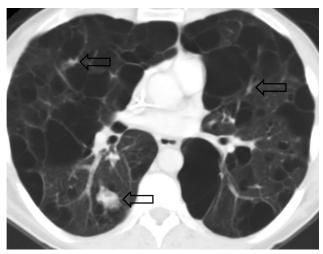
Chest computed tomogram reveals extensive bilateral bullous changes and multiple parenchymal nodules (arrows).
